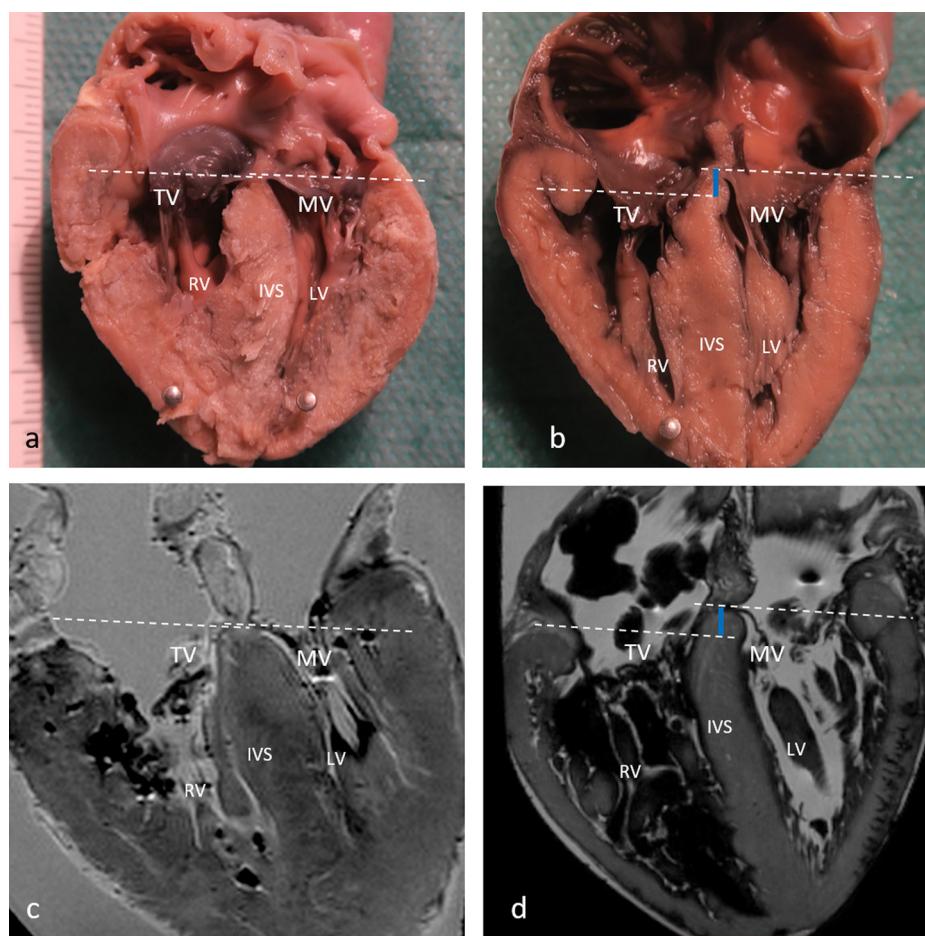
Evaluation of the differential insertion of mitral and tricuspid valves on autopsy (a; b: top) and MRI four-chamber views (c; d: bottom) with: linear insertion of atrioventricular valves (LIAVV) (a; c: case 4) and normal insertion (b; d: case 6). In normal heart, the tricuspid valve inserts closer to the cardiac apex compared with the mitral valve (dotted lines). In LIAVV, a horizontal continuity of the septal insertion of mitral and tricuspid valves exists. The distance between the insertion of atrioventricular valves (blue lines) is greater in normal heart compared with LIAVV regardless of the technique of measurement (TV: tricuspid valve; MV: mitral valve; LV: left ventricle; IVS: interventricular septum).
